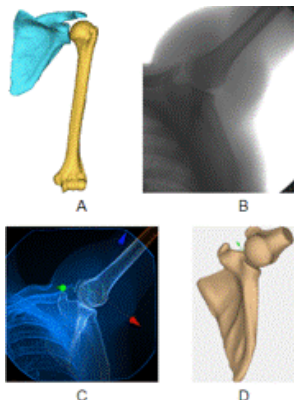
Subject-specific, CT-derived bone models (A); Dynamic videoradiography (B); 2D-3D Shape matching (C); 3D kinematics (D)
